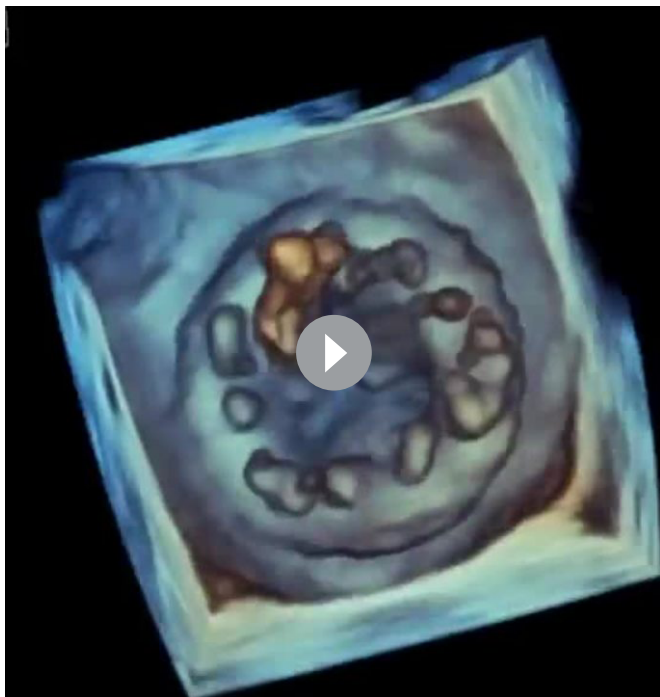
Three-dimensional transoesophageal views of the of the prosthetic mitral valve as seen from the left atrium ('surgeons view'). There was growth of the vegetation size and profound increase of the regurgitation from admission at the university hospital (A and C) to the day before surgery (B and D).
